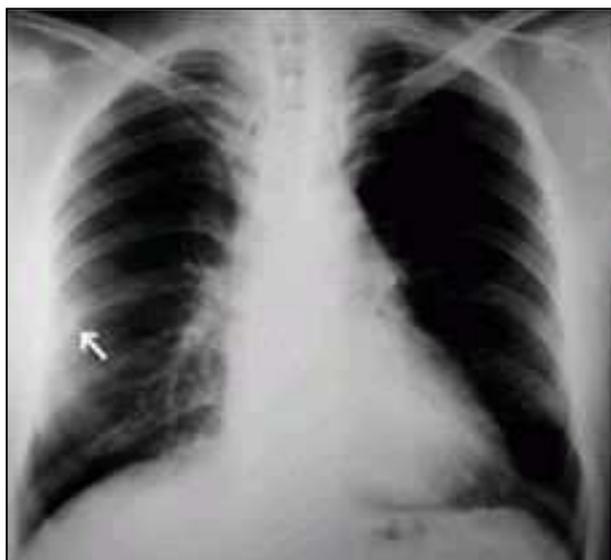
Chest radiograph showing fracture of the right eighth rib (arrow).
